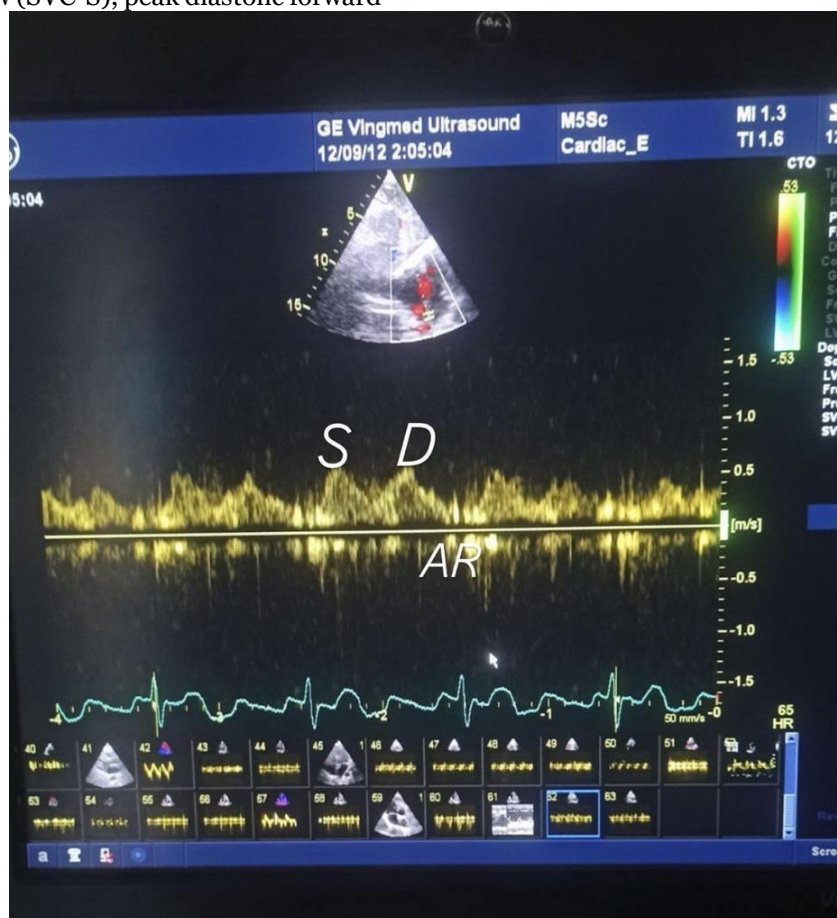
PW, Doppler measurement of superior vena cava (SVC) flow velocity
